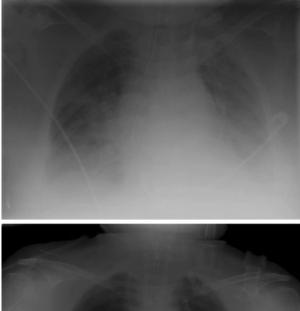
Chest X-ray before (*top*) and 24-h after (*bottom*) patient was placed in prone position. Note that the central venous catheter was changed just after the end of the prone positioning session because the insertion point was inflamed
